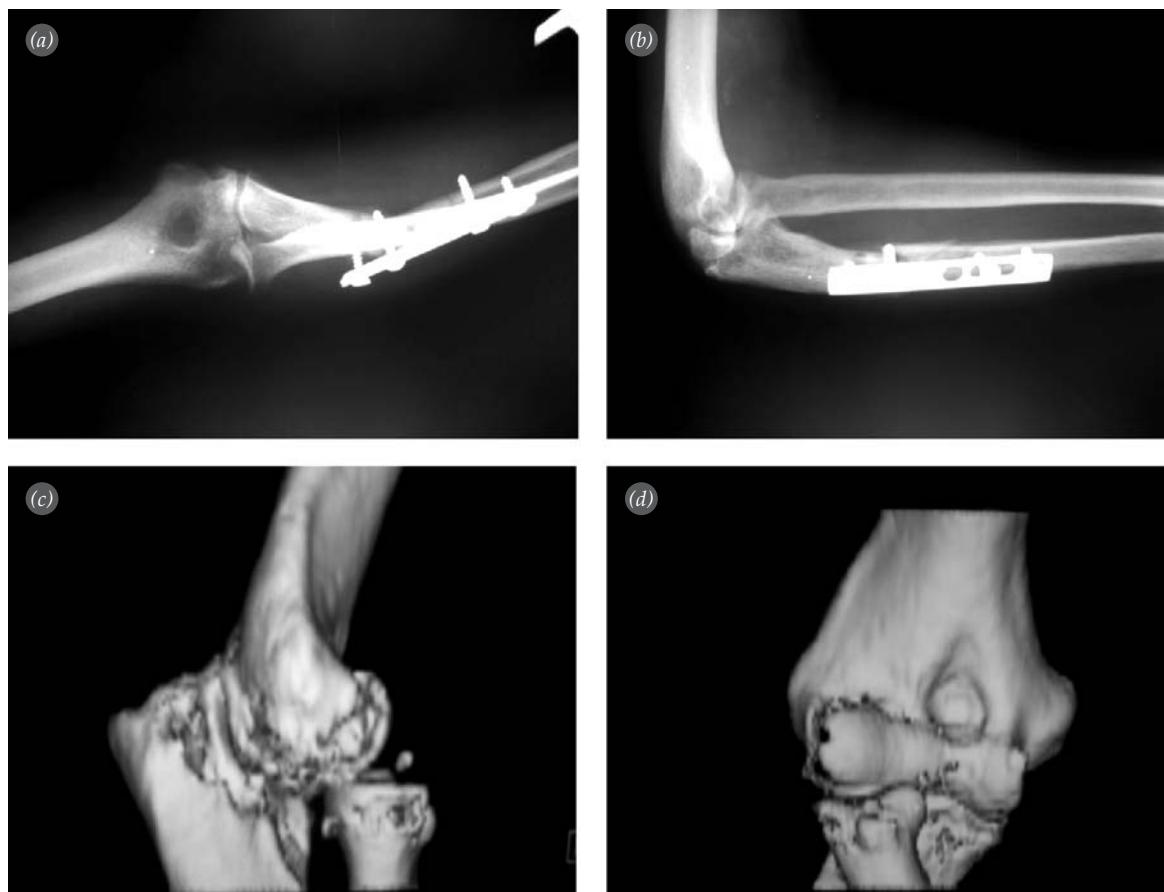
Preoperative (a) AP, (b) lateral X-rays and (c, d) 3-D CT images. Delayed union of ulna and fractures of radial head are seen.
